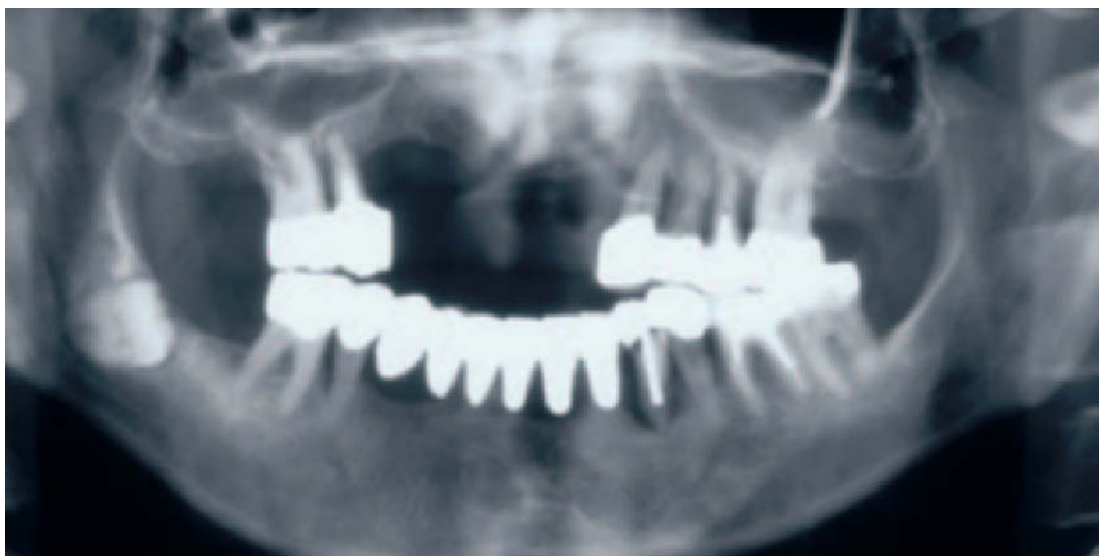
Panoramic radiograph of patient with advanced periodontal and cariogenic disease in his residual dentition of the upper jaw. Note the traumatic loss of the anterior teeth.
